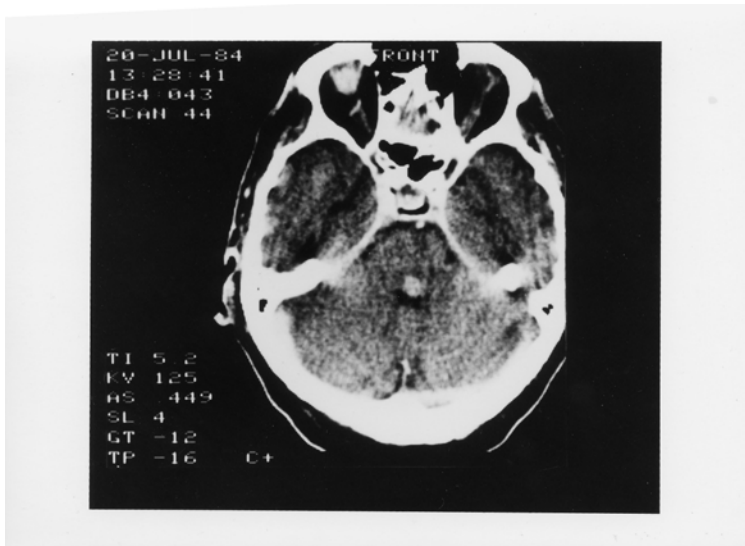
Case 11-1. *CT scan* indicating a more prominent enhancing lesion at the level of the facial colliculus
